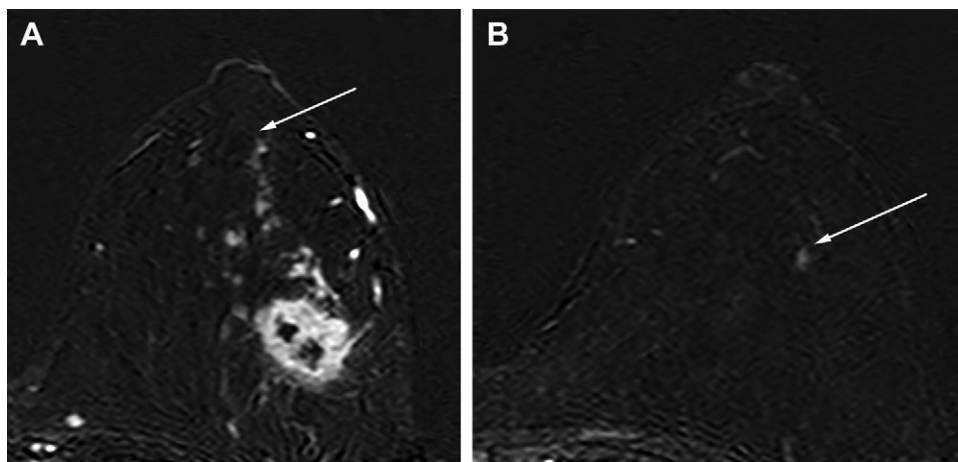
MRI scans in a 51-year-old woman with hormone receptor–positive and human epidermal growth factor receptor 2–negative breast cancer without nonmass enhancement (NME) extension to the nipple on MRI scans acquired before and after neoadjuvant chemotherapy (NAC). The patient was administered four cycles of anthracycline and cyclophosphamide every 3 weeks, followed by 12 cycles of weekly paclitaxel. (A) MRI scan acquired before NAC shows that NME extends toward the nipple but does not reach the nipple base (arrow). (B) After NAC, the extent of NME appears markedly reduced without NME extension to the nipple (arrow). Tumor invasion of the nipple was not found at pathologic evaluation.
